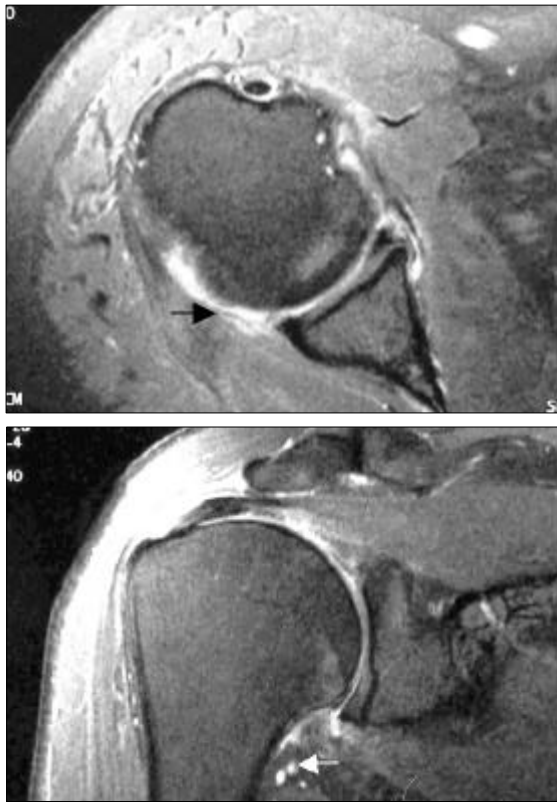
Magnetic resonance image of the right shoulder in patient 2 shows an irregular articular margin (black arrow) and small axillary pouch (white arrow).
